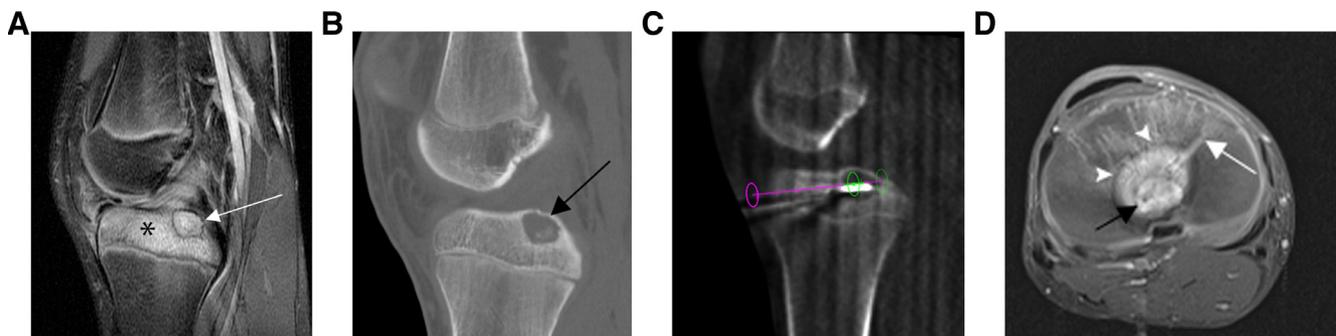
A 15-year-old boy with a painful osteochondroma of the tibial epiphysis. (A) Sagittal T2-weighted MR image of the knee demonstrates the well-circumscribed T2-hyperintense lesion (arrow) with surrounding bone marrow edema (asterisk). Sagittal CT image (B) shows a lucent lesion with internal chondroid matrix (arrow). An intraoperative sagittal cone-beam CT image (C) utilizing software guidance demonstrates a cryoprobe within the lesion. A 1-month follow-up axial T2-weighted MRI image (D) shows the treated lesion (black arrow) with surrounding cryoablation zone (white arrowheads) and ablation tract (white arrow).
